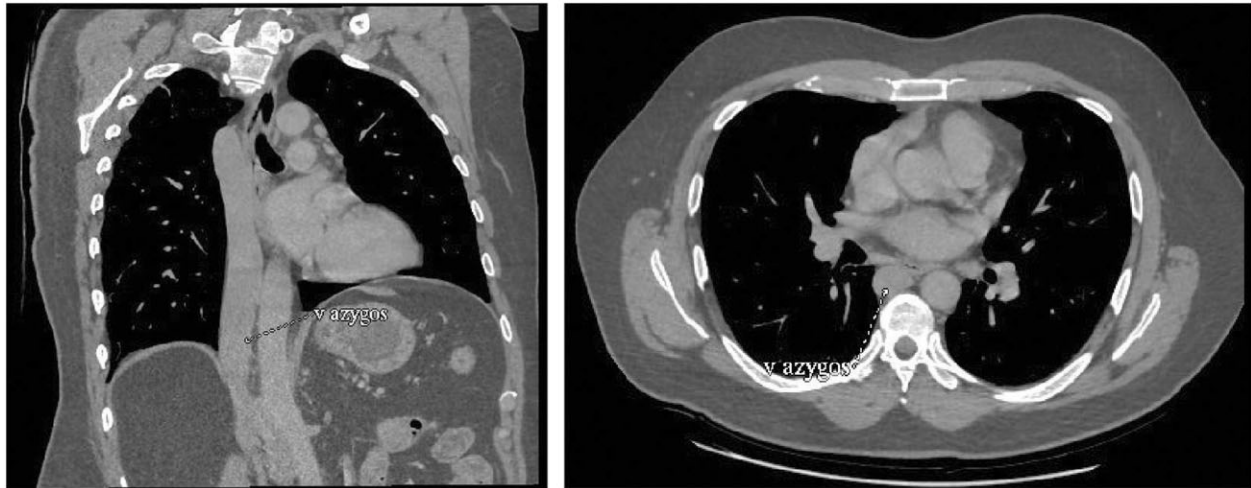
Coronal and axial view of previous computed tomography angiography scan revealing that inferior vena cava is interrupted at hepatic level.
